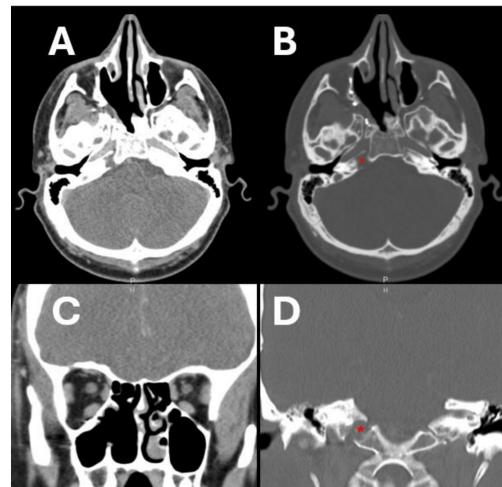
Postoperative head CT axial (A, B) and coronal (C, D) views at 18 months follow-up after endoscopic endonasal resection of JNA showing gross total resection. Note the bony lesion at the right petrous apex (red asterisk in B and D) was stable.
